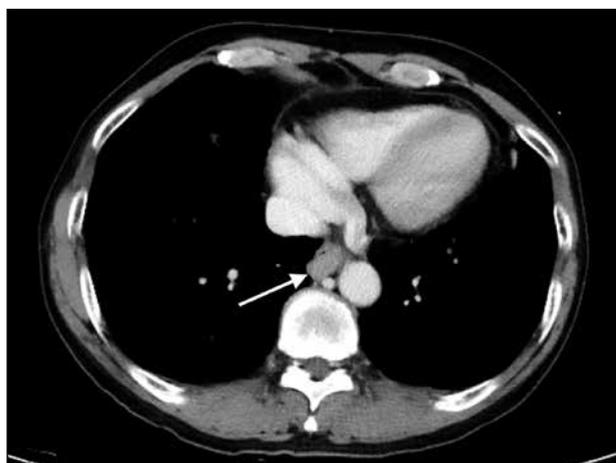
Suspected oesophageal leiomyoma in a 73-year-old man. Contrast-enhanced computed tomography showing a small homogeneously enhancing mass at the lower oesophagus (arrow).
